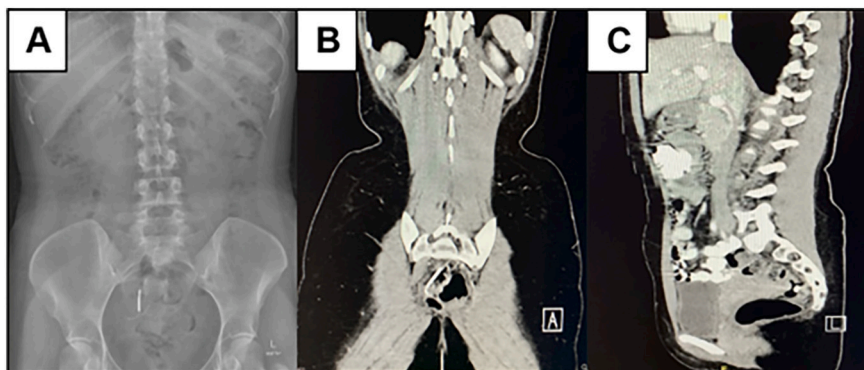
Findings on imaging. (A) Abdominal X-ray showing an IUD within the lower abdomen, outside the uterine cavity, (B and C) CT scan localising the misplaced IUD which appears to be perforating the anterior rectal wall.
